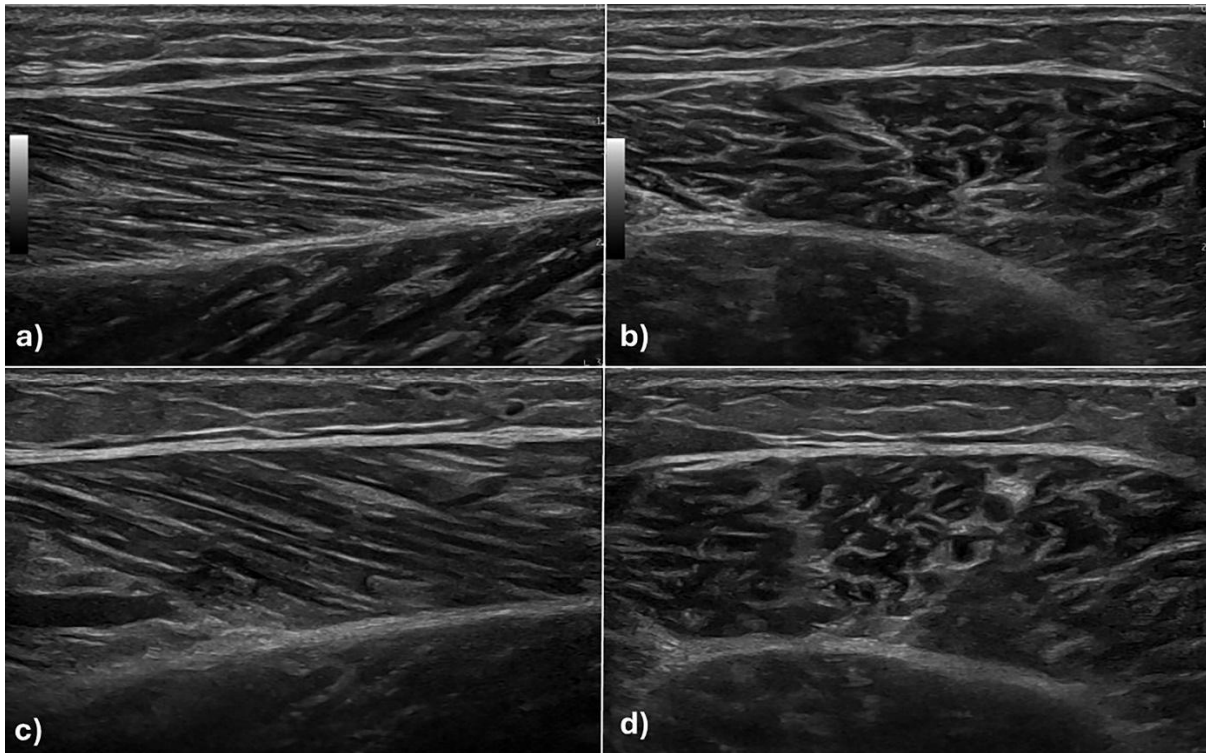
The gray scale ultrasound appearance of muscles at rest or in a relaxed state (a) in a longitudinal plane has a “comb” appearance due to the alternation of hypoechoic linear zones corresponding to muscle fascicles and parallel hyperechoic lines, and (b) in a transverse plane, it has a “starry” appearance due to multiple hyperechoic dots and lines on a hypoechoic background. The ultrasound appearance of muscles during isometric contraction (c) in a longitudinal plane (d) in a transverse plane, an increase in muscle size can be observed, a decrease in overall echogenicity, and an accentuation of the obliquity of muscle fibers
